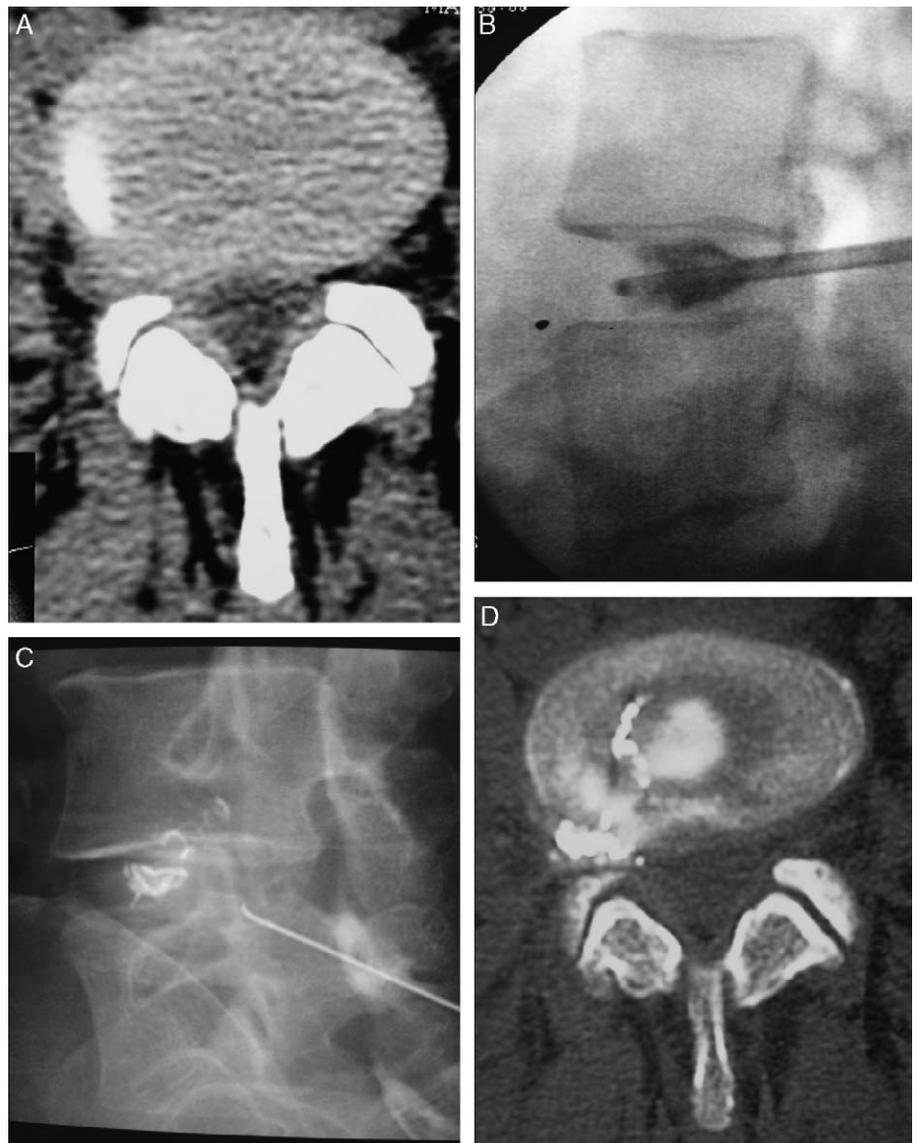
Foraminal hernia treated by "triple therapy" (RGE, APD, intra-articular steroid injections) very good clinical result. A, CT before treatment. B, Intradiscal treatment (RGE+APD). C, Intra-articular steroid infiltration. D, CT after treatment: RGE concentrated in the hernia.
